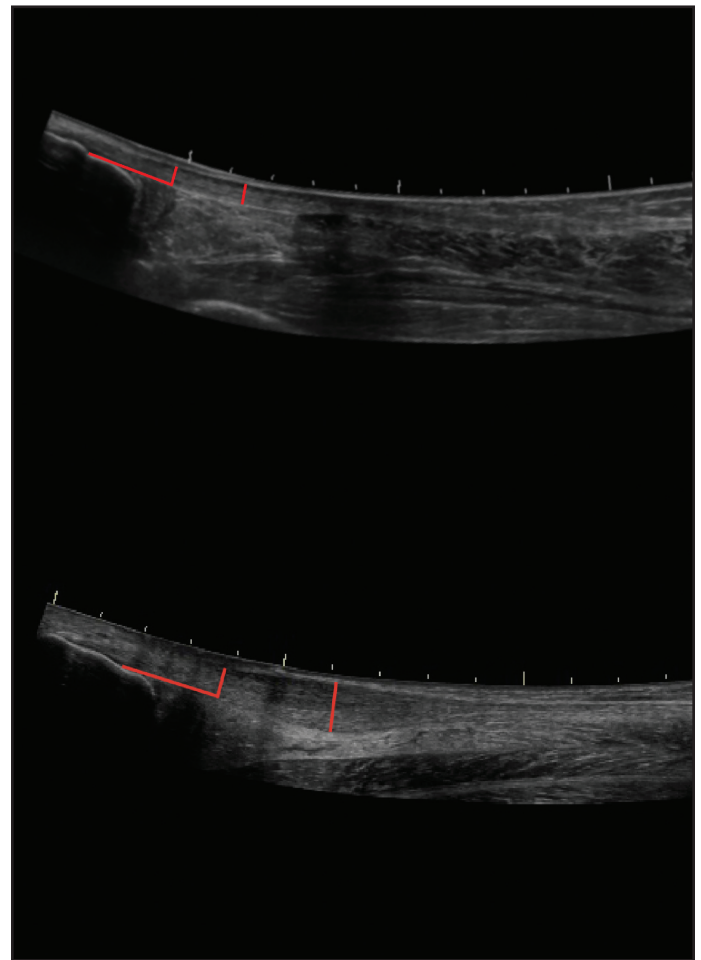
Representative ultrasound images. Top Image–Healthy Achilles tendon. Bottom Image– Achilles tendon with tendinosis. Lines demonstrate how tendon thickening was calculated. Tendon Thickening = Thickness at the thickest portion - Thickness 2 cm proximal to the calcaneal notch).
